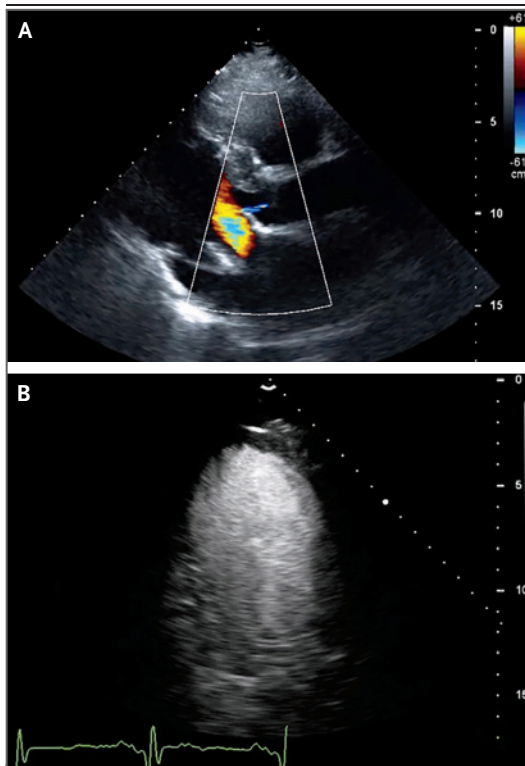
Echocardiogram Obtained before Electrophysiologic Catheter Ablation.
